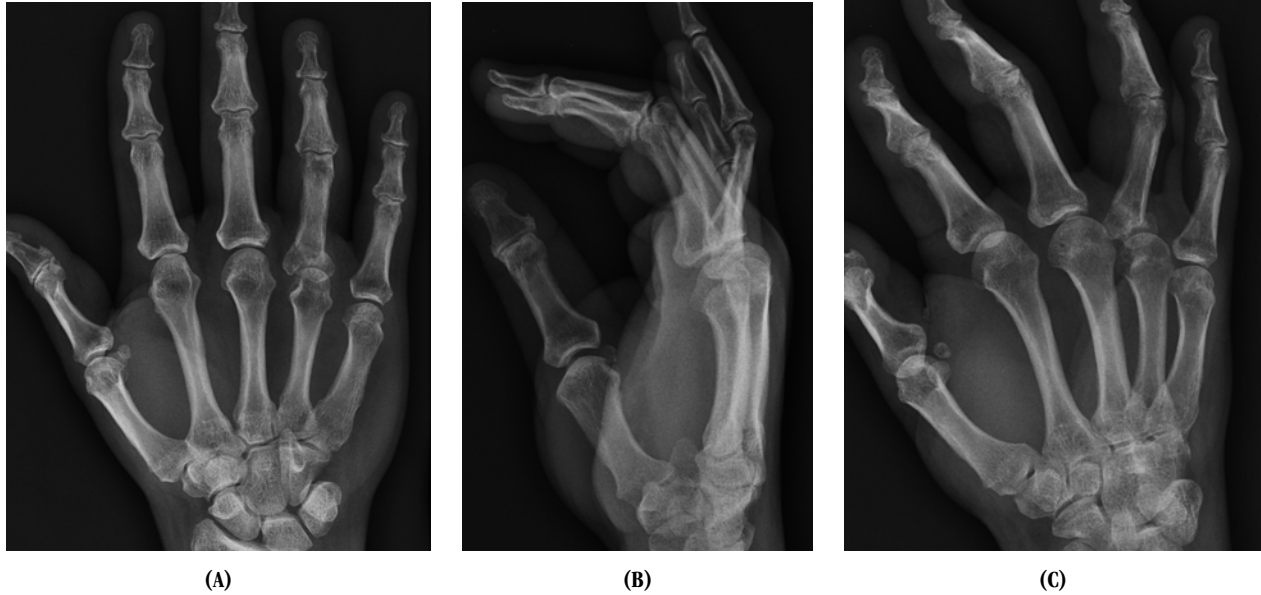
(A) AP (B) lateral and (C) oblique radiographs of ring finger proximal phalanx malunion. Dorsal malunion measures 35° apex anterior with no obvious rotatory deformity.
